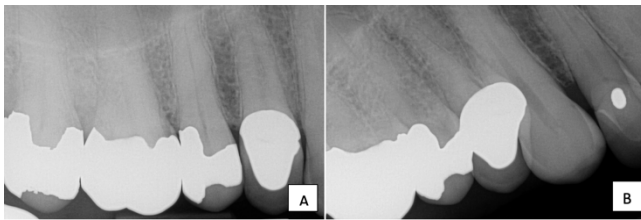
Periapical diagnostic radiograph of tooth #24, centered view (A), and distal shift (B) showed three roots in the permanent maxillary right first premolars.
